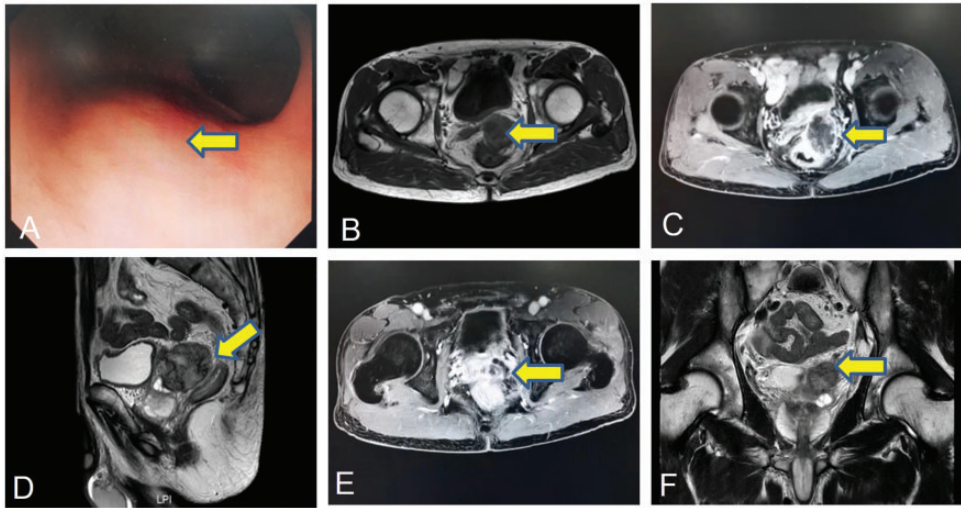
Imaging examinations of a 68-year-old male that presented with a 6-month history of lower abdominal intermittent colic and weight loss of 5 kg: (a) colonoscopy images of the tumour; (b) T1-weighted magnetic resonance imaging (MRI) in the axial position; (c) enhanced MRI in the axial position; (d) T2-weighted MRI in the sagittal position; (e) enhanced MRI in the axial position demonstrating invasion of the left seminal vesicle and (f) enhanced MRI in the coronal position demonstrating invasion of the left seminal vesicle. The yellow arrows show the location of the tumour. The colour version of this figure is available at: <http://imr.sagepub.com>.
